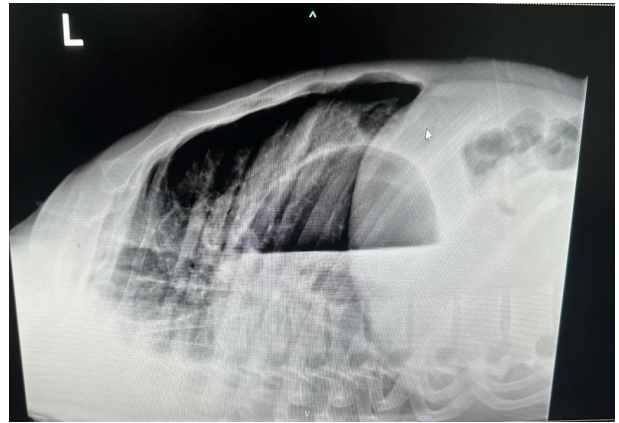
Lateral decubitus chest X-ray demonstrating the air-fluid level.
